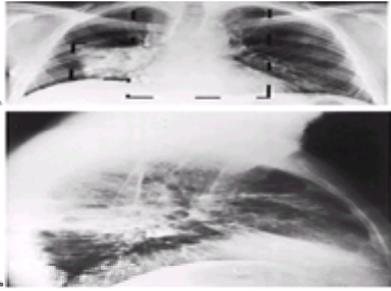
Posteroanterior (A) and lateral (B) roentgenograms of a patient who initially presented with inoperable primary carcinoma of the right-lower-lobe bronchus, for which he received radiation therapy. These roentgenograms were taken on routine follow-up 7 months after therapy—the patient was asymptomatic. The outline of roentgenographic changes exactly follows the margin of the port, allowing for contraction due to fibrosis and the fact that treatment films are taken supine. The lateral picture (B) shows the opacity running the full depth of the lung, again corresponding to the x-ray beam. The patient received no further treatment and remained asymptomatic without roentgenographic progression of the lesion. Diagnosis: radiation fibrosis.
